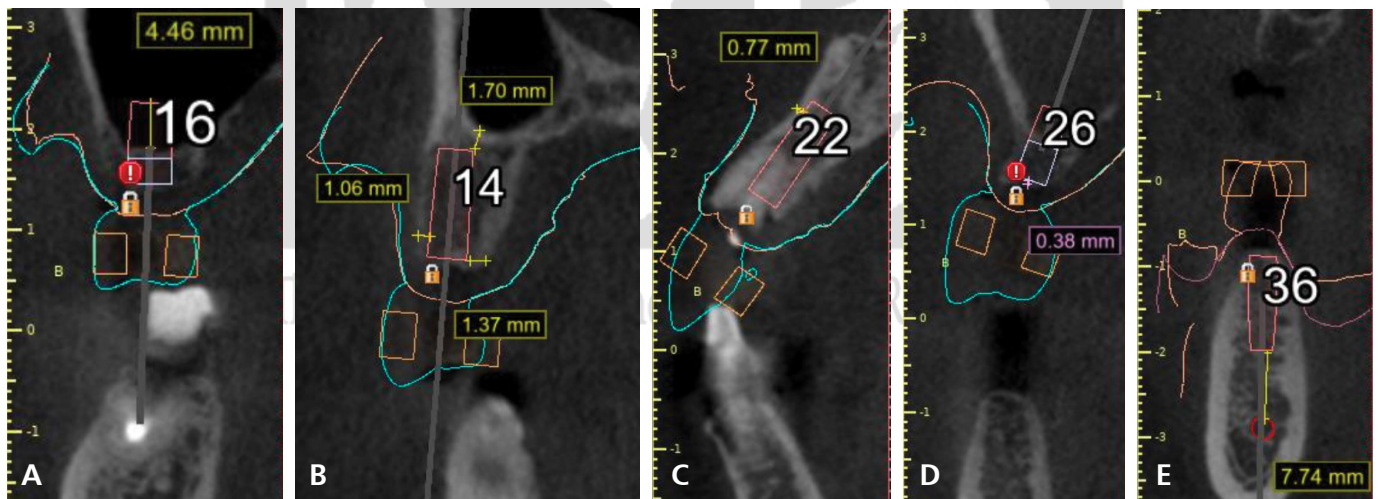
CBCT images analysis of the implant sites bone condition. (A) 16. (B) 14. (C) 22. (D) 26. (E) 36.
